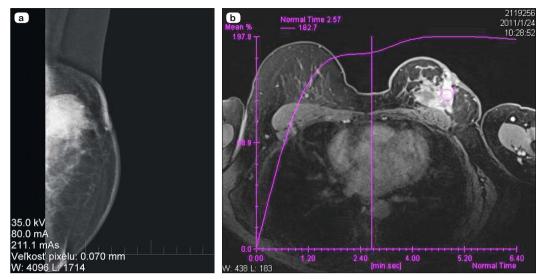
(a) Mammography of the left breast – MLO projection – increased density of fibroglandular tissue with focal appearance in the upper quadrant of the left breast, (b) MRI of the breast-dynamic contrast enhanced study – markedly enhanced infiltration with retractive changes and middle to high proliferating activity.
